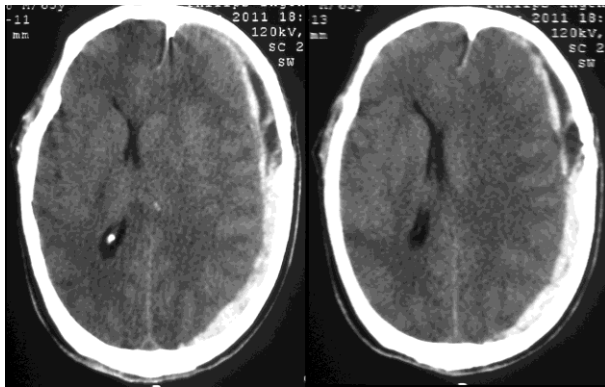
Plain computed tomography scan brain showing large acute left frontal-temporo-parietal subdural hematoma with mass effect and midline shift.
